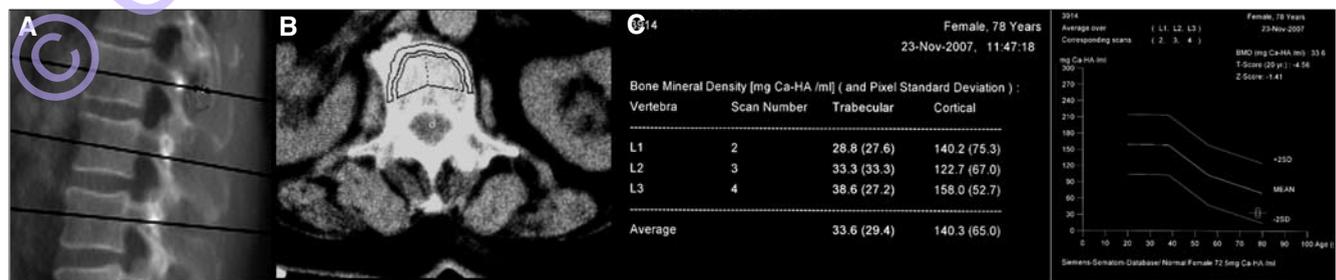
A) Lateral scan projection radiograph with identification of slices to be performed at L1-L3 ; B) PacMan region of interest selected to encompass trabecular bone area without including the cortical shell or the basi-vertebral vein area (48) (49); C) L1-L3 trabecular and cortical BMD results.
